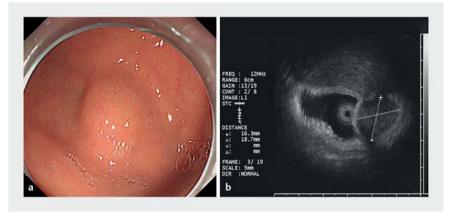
Endoscopic ultrasonography view images of a gastric stromal tumor in the fundus of stomach.
